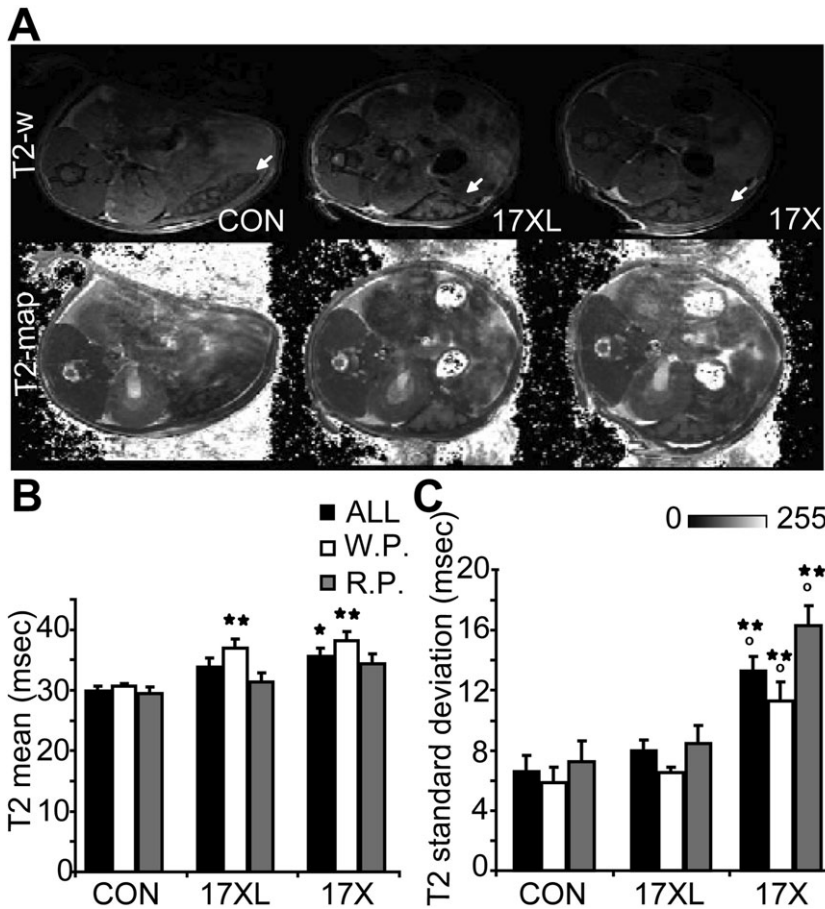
MRI of the spleen using T2 relaxometry.
